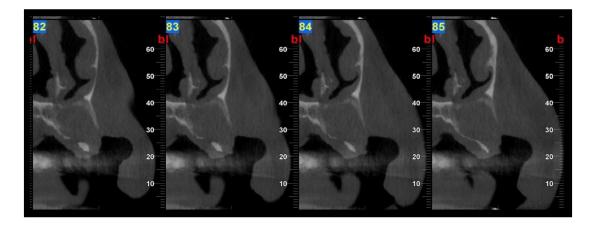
(Post-operative CBCT images (4 months after the surgery).)
